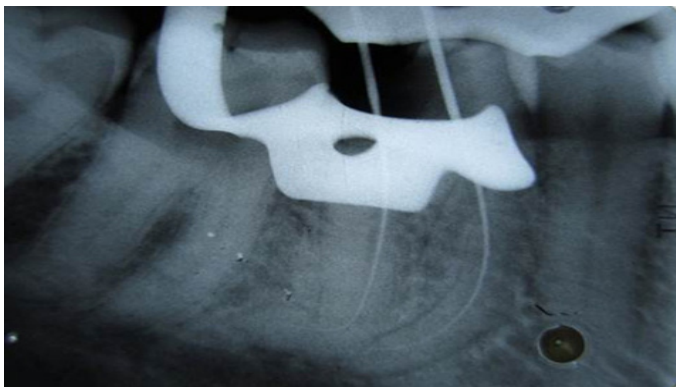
Intraoral periapical radiograph showing working length determination.
